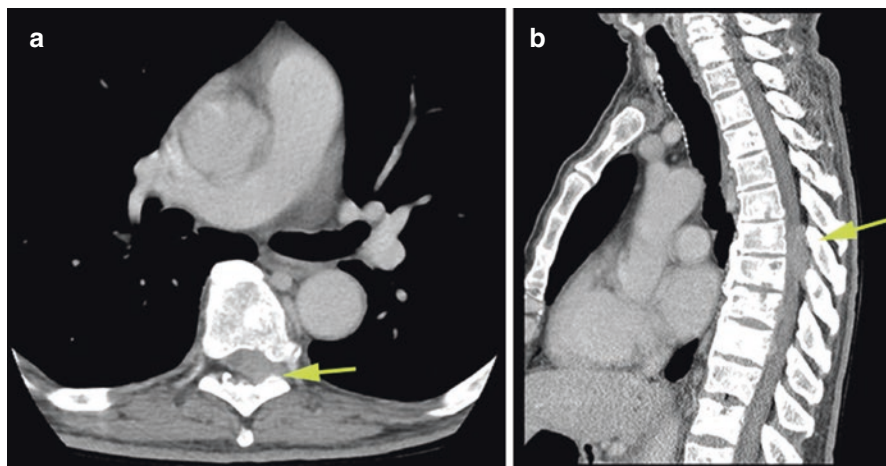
(a, b) Axial and sagittal non-contrast CT showing extradural masses compressing T6–T9. Areas of previously metastatic spine tumor from prostate cancer are visible throughout the spine. Due to quick neurological decline, and salvageable neurological function, patient went to surgery directly after non-contrast CT
